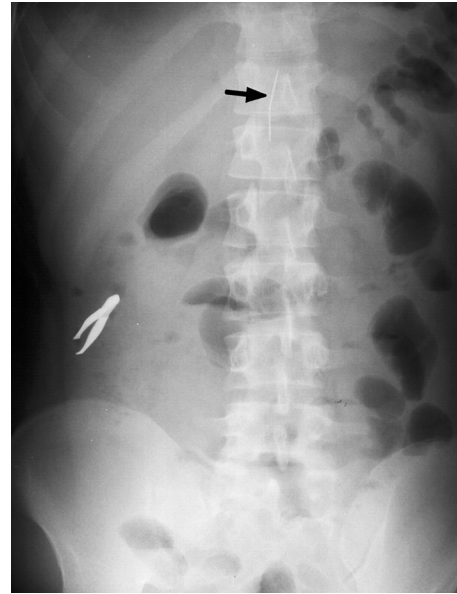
Plain abdominal radiograph showing the ingested tweezer and a needle-like object in the upper abdomen (arrow).
